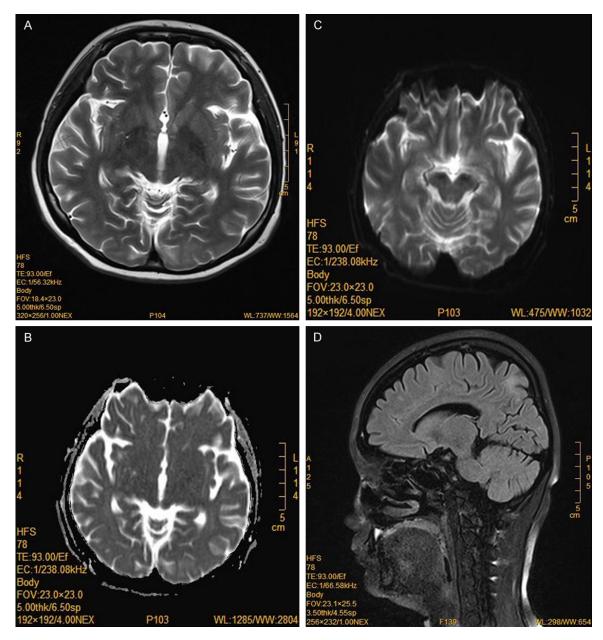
Brain magnetic resonance image 12 days after discontinuing Mycophenolate. Complete resolution of high signal intensities is shown compared with Figure 3.
